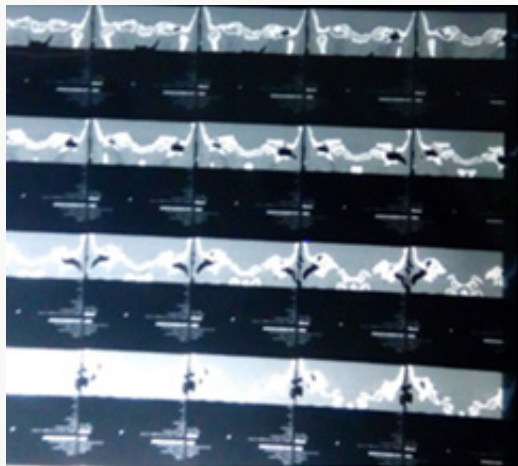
HRCT Temporal bone coronal view.
